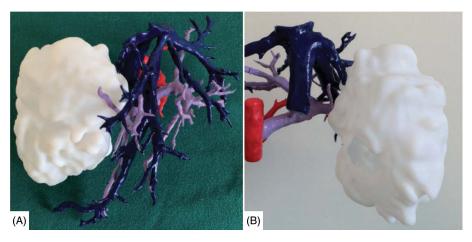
Three-dimensional (3D) representation of a printed model of a hepatic tumor in a child: (A) anterior view and (B) posterior view. The tumor is represented in white, the hepatic vein is shown in blue, the portal vein is in purple, and the artery is red. The data from computed tomography were converted to .stl format files, which were then electronically delivered to a 3D printer to be printed with photosensitive resin.
